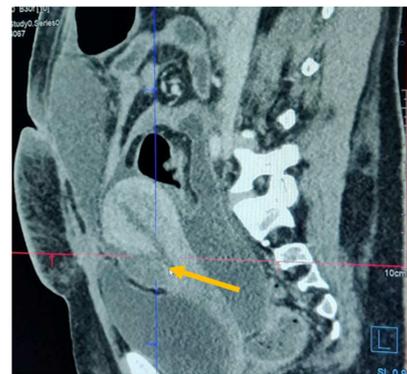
CT scan image suggestive of suture site uterine dehiscence (marked by arrow), chronic collection in POD and collection beneath the suture site and pre-peritoneally.
